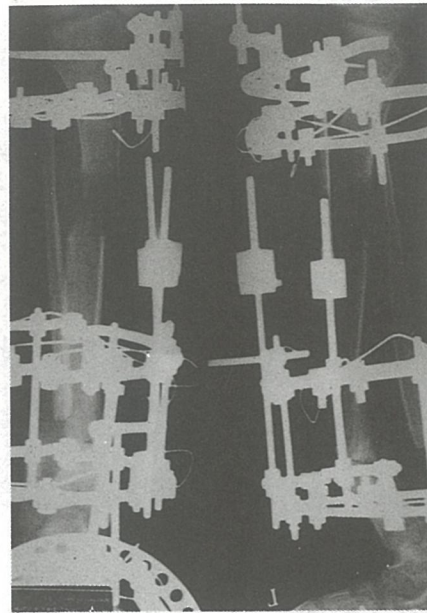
B The radiograph of the congenital pseudarthrosis of the tibia after application of a ring external fixator, there was anterior angulation at the pseudarthrosis site which was failure to unite.
